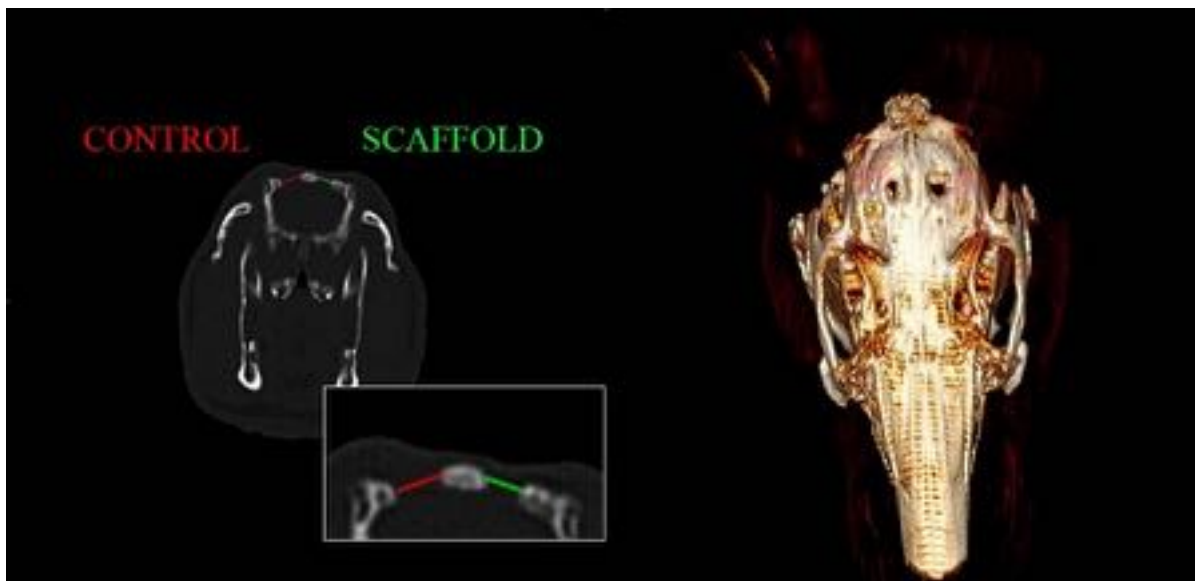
CT scan and 3D reconstruction at 12 weeks. A comparison of the diameters of treated versus untreated bone defects is demonstrated in the coronal view.
